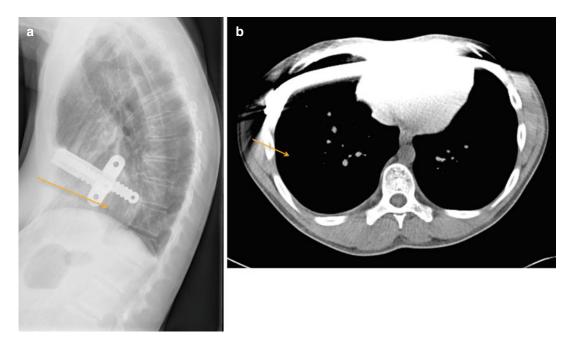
Too lateral entrance of the support bars positions the support bars intrathoracic and fails to elevate the defect anteriorly. (a) posteriorly displaced bar is seen on in this patient's lateral chest roentgenogram. *Arrow* point to pectus excavatum defect still seen
